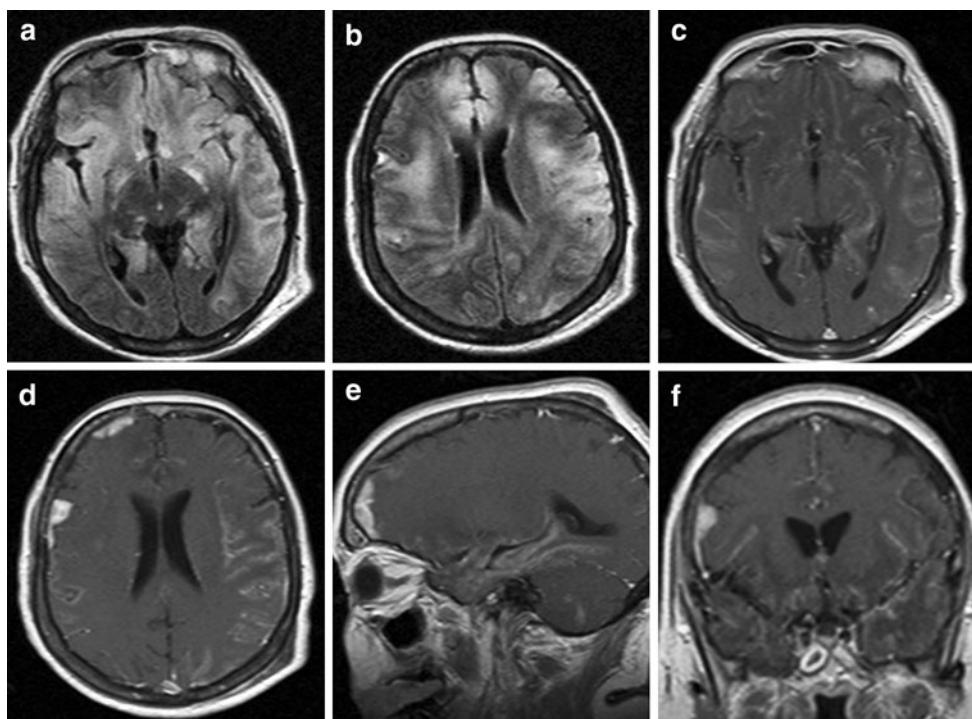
MRI performed with the FLAIR sequence in the axial plain (a, b), and spin-echo T1 after gadolinium-DTPA infusion in the axial (c, d), sagittal (e), and coronal (f) planes shows a diffuse hyperintensity signal in the frontal, parietal, and temporal lobe bilaterally. A bilateral leptomeningeal enhancement is shown after gadolinium-DTPA infusion
